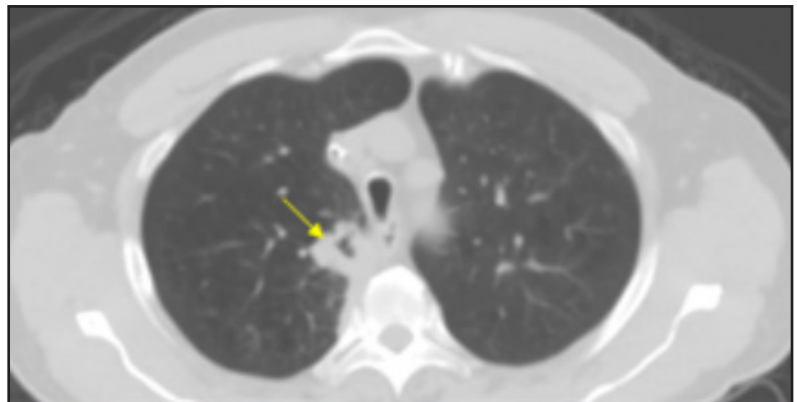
Metastasis. Axial unenhanced CT and fused F-18 fluorodeoxyglucose (FDG) PET/CT images demonstrate a cavitary right upper lobe mass (yellow arrow) with FDG avidity (red arrow) and history of head and neck squamous cell carcinoma.
